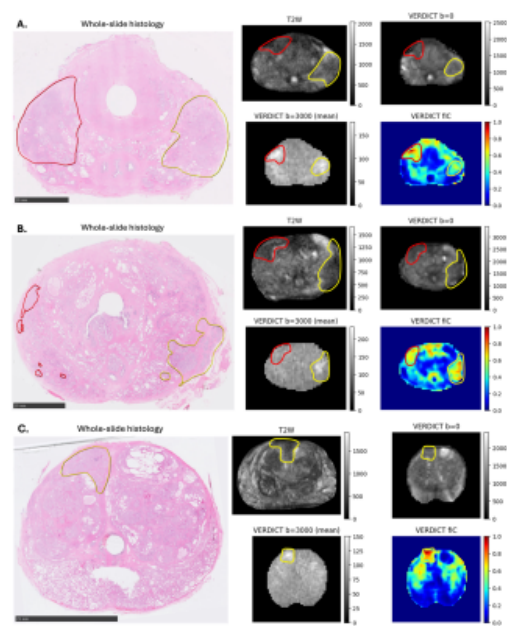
Examples where median fIC of invisible lesions is above threshold. Invisible lesions are outlined in red, reported lesions in yellow. A. Reported lesion in left posterolateral base of PZ (Likert 4, GS 3+4). Non-reported GS 3+4 lesion on the right, visible on VERDICT-MRI. B. Reported lesion in left posterolateral apex to base of PZ with some extension into left TZ (Likert 5, GS 4+3 with perineural invasion). Non-reported GS 3+4 lesions on the right, visible on VERDICT-MRI. C. Reported lesion in right TZ (Likert 2, GS 3+4). Could have been upgraded to higher Likert with VERDICT-MRI.
